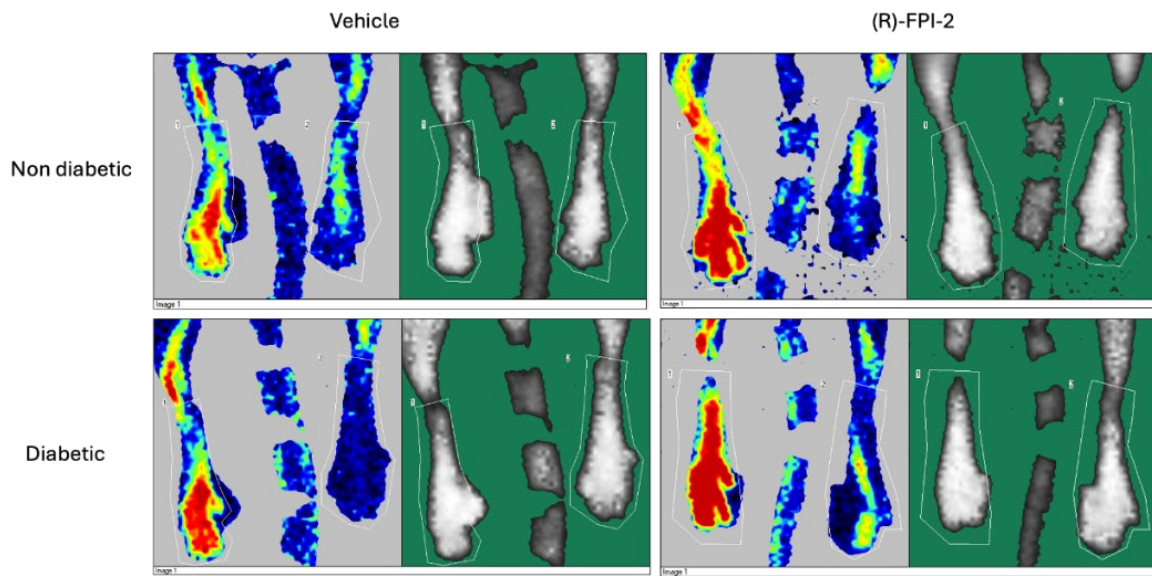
Region of interest (ROIs) used for the analysis of limb perfusion by laser Doppler Imaging in the different experimental groups.
